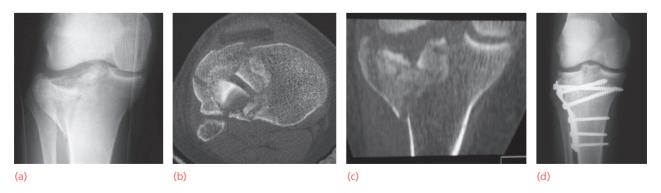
Tibial plateau fractures – imaging (a) X-rays provide information about the position of the main fracture lines and areas of articular surface depression. (b,c) CT reconstructions reveal the extent and direction of displacements, vital information for planning the operation. (d) The postoperative X-ray shows that reduction has been achieved.
